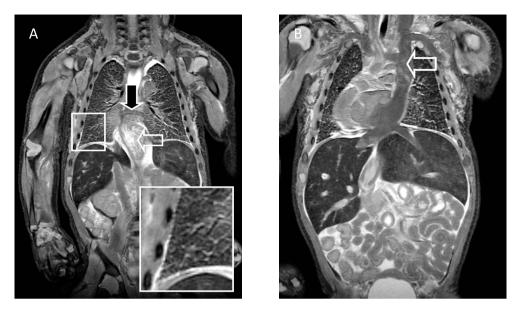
A neonate with a congenital cyanotic heart disease born at 39 weeks. Maximum support and 100% oxygen did not lead to clinical improvement and the child died. T2-W coronal MRI shows a complete anomalous venous return (arrow) with pulmonary interstitial oedema (insert). A central tendon defect is seen (open arrow) (slice thickness: 2 mm, TR: 5500, TE: 54, FA: 180°). Figure 6b. T2-W coronal MRI shows a persistent left superior caval vein (arrow), a dextrocardia and situs intermedius of the liver. Asplenia was also noted.
